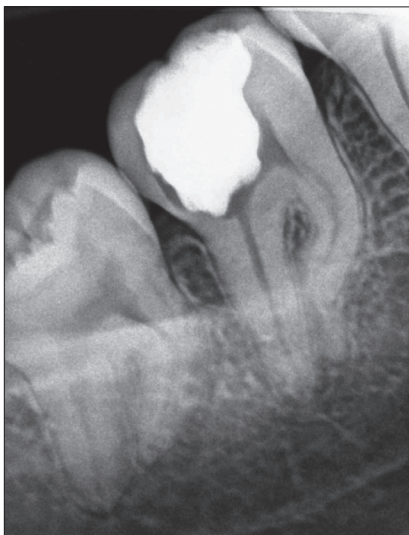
Initial periapical radiograph revealing presence of a deep temporary restoration and accentuated curvature of mesial root in tooth #47.
